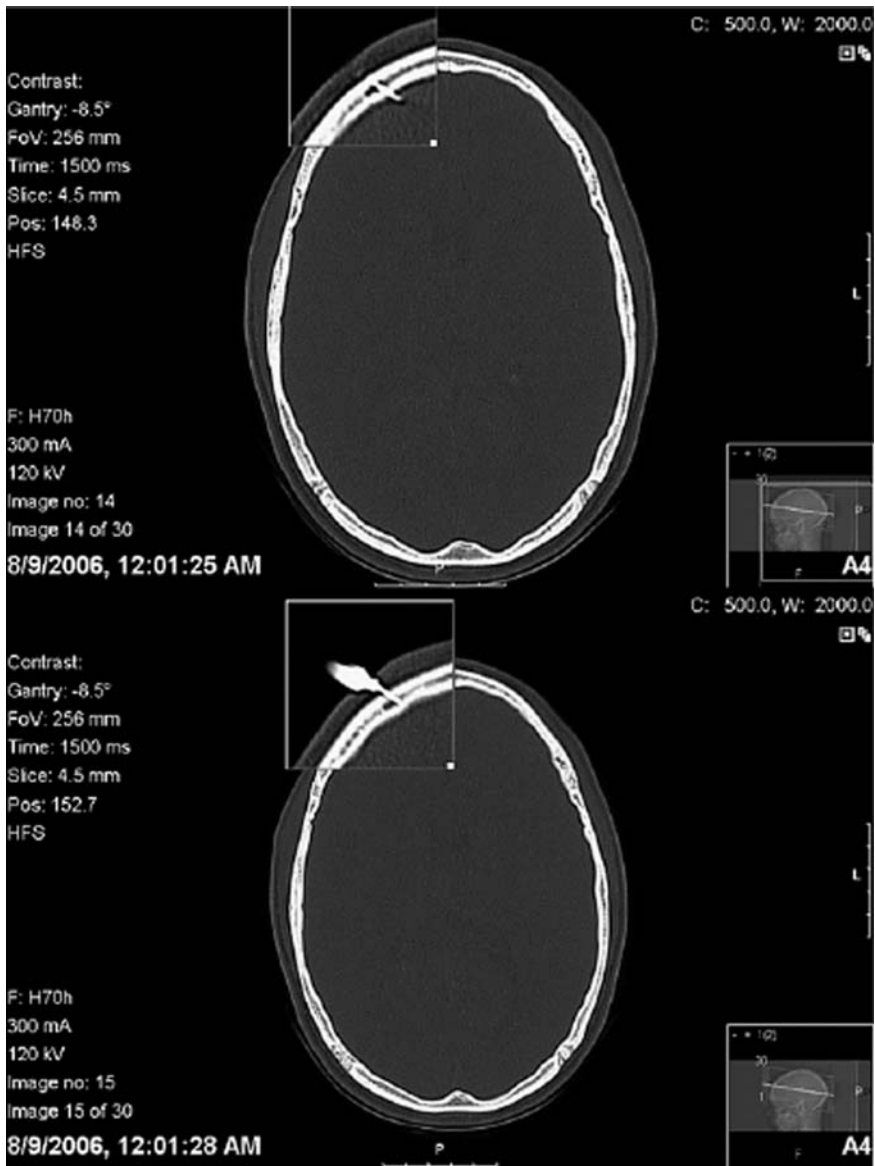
A computed tomographic scan of the head revealing intracranial penetration of the dart and possible dural perforation (reproduced with permission from [10])
